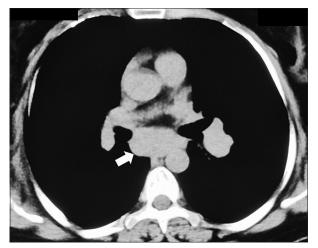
Computed tomography of the chest showing enlarged left interlobar and subcarinal lymph nodes (arrow)
